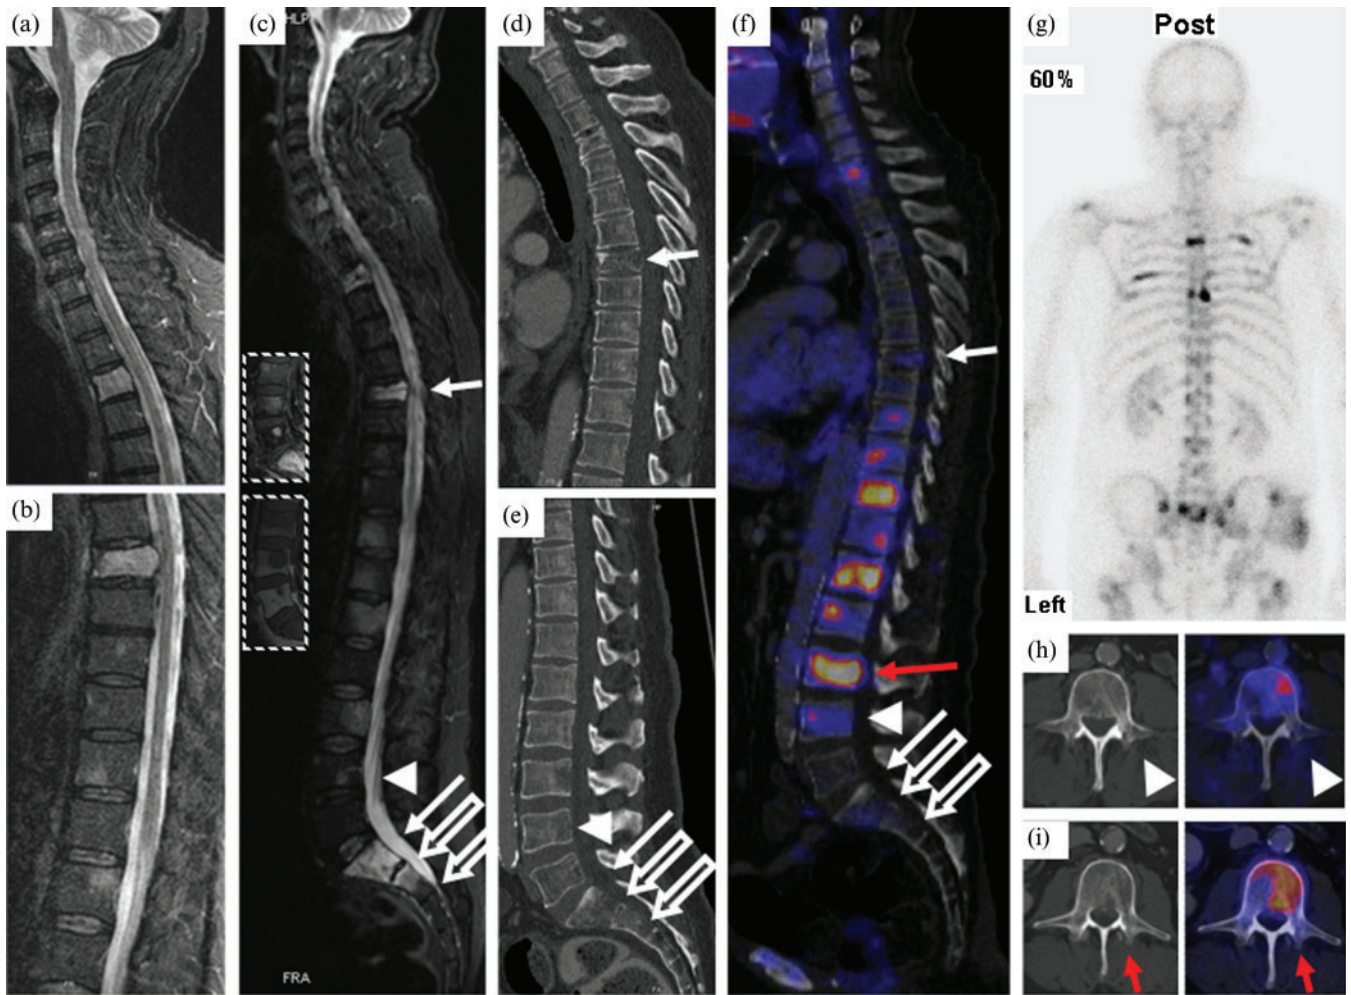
(a,b) Outpatient MRI of the spine (T_2 weighted turbo inversion recovery magnitude (TIRM) FS) showing vertebrae C1–T5 (a) and T6–L2 (b) prior to radiation therapy. Multiple hyperintense lesions representing vertebral metastases to T3, T7, T11–12, L1, L3, S1–2 and a compression fracture of T7 protruding into the spinal canal are visible. (c) MRI of the spine after radiotherapy (T_2 weighted TIRM fat-saturation (FS); insets, T_1 weighted turbo spin-echo (TSE) with gadolinium intravenous contrast (top) and T_1 weighted TSE (bottom) of L3–S1). Hyperintense lesions appear unchanged in radiated regions. (d,e) Sagittal CT of the thoracic (d) and lumbar (e) spine showing the compression fracture of T7 and inhomogeneous bone structure but no apparent osteolysis. (f) Positron emission tomography (PET)/CT fusion image of the vertebral column with previous biopsy sites (solid arrows, transpedicular biopsy of vertebrae T7 and S1; open arrows, surgical (open) biopsy of vertebral bodies S1 and S2; arrow heads, transpedicular biopsy of vertebra L4) and biopsy site chosen according to PET/CT (red arrow). (g) Bone scintigraphy showing increased uptake of ^{99m}Tc -DPD in several ribs on the left and right hemithorax, as well as in the vertebral column. (h) PET/CT fusion image of L4: the biopsy channel is visible adjacent to FDG-avid, potentially vital malignant tissue. (i) Retrospective fusion of PET data (right) with post-biopsy CT (left) after PET/CT-planned biopsy of vertebra L3.
